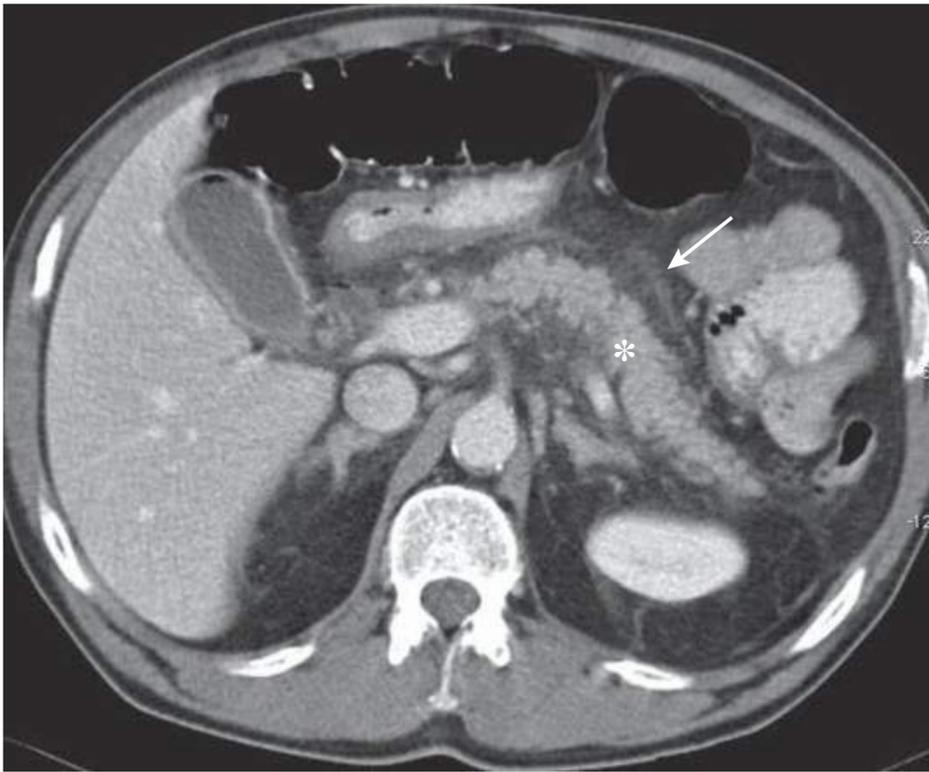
Interstitial pancreatitis. Computed tomographic image of a swollen pancreas (*asterisk*). Fat stranding is seen around the pancreas (*arrow*). (From Bollen TL. Acute pancreatitis: international classification and nomenclature. *Clin Radiol.* 2016;71:121-133.)
